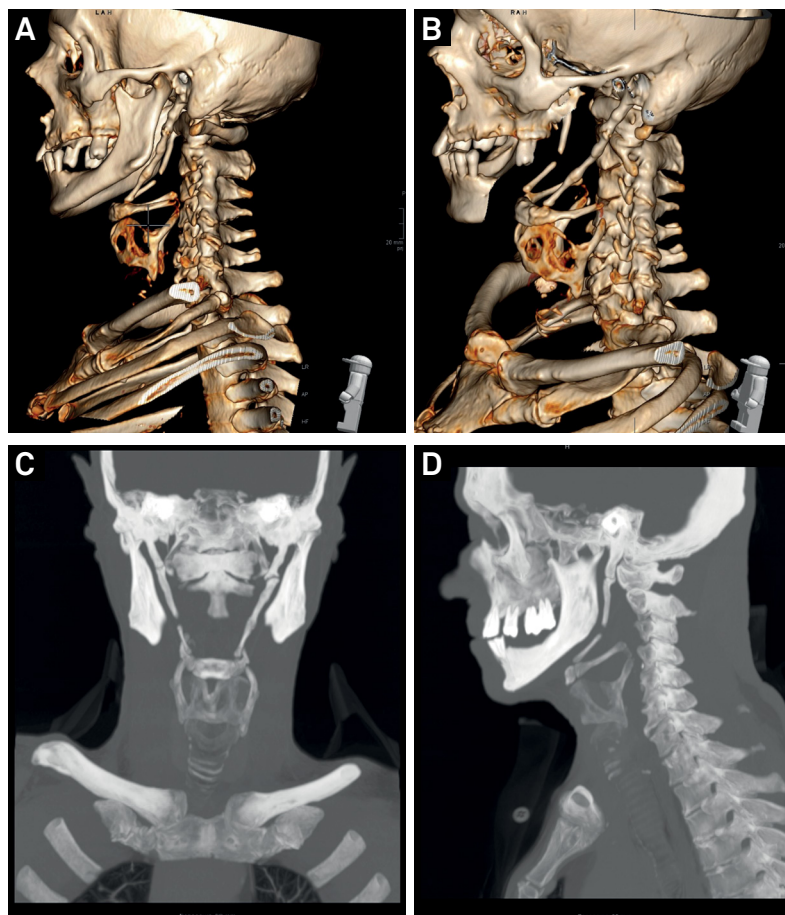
Maximum intensity projection and 3D CT-scan volume rendering of the patient's cervical region. Note bilateral calcification of the stylohyoid ligament.
